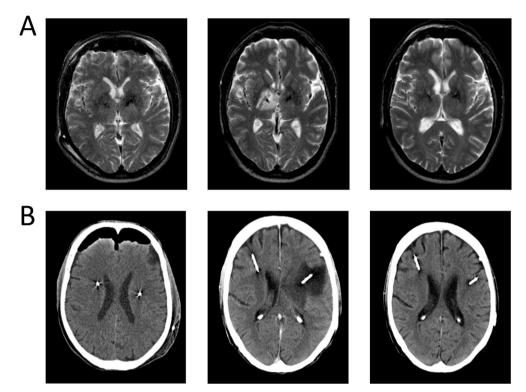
(A) Patient 3. Early postoperative routine T2 MRI (Day 1) showing no abnormalities except for minimal pneumocephalus; T2 MRI 305 days after surgery, showing edema along the right lead; T2 MRI 92 days after symptoms onset showing resolution of edema. (B) Patient 10. Early postoperative routine CT showing no abnormalities except for bilateral pneumocephalus; contrast CT 15 days after surgery, showing edema along the left lead; contrast CT 60 days after symptoms onset, showing resolution of edema.
